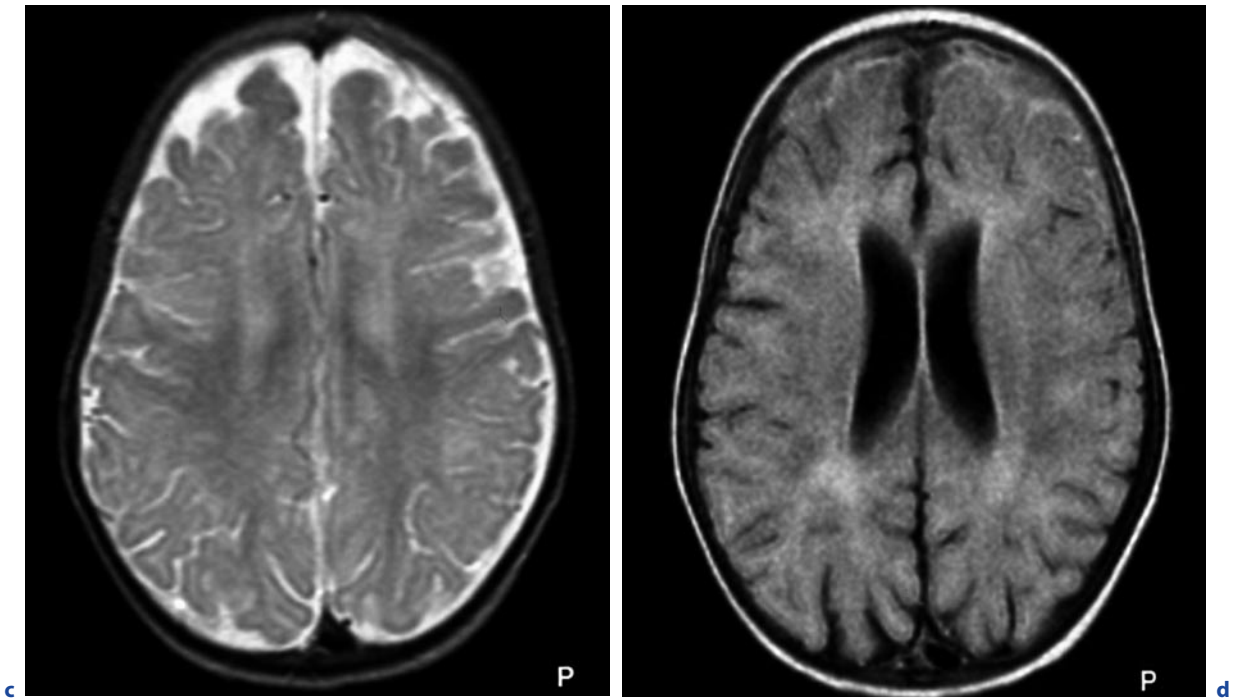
(continued) Pneumococcal meningitis in a 5-year-old child. c Axial T2-weighted image. d Axial FLAIR image. Bifrontal subdural exudates (c,d) with relatively high
